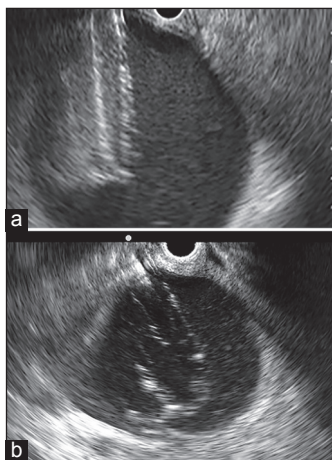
(a and b) Hydrostatic balloon dilatation of the transmural tract under endoscopic ultrasound guidance
